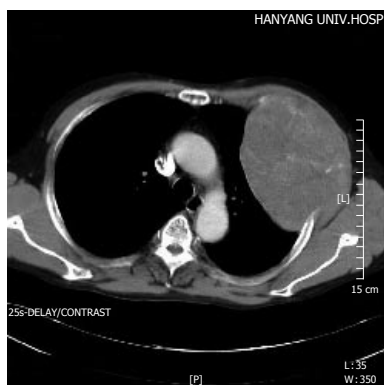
Chest helical CT. A mass on the anterolateral aspect of the left chest wall. The inner part of the mass is heterogeneously attenuated and consistent with mottled calcification. There is no evidence of metastasis in the mediastinum or the lung parenchyma.
